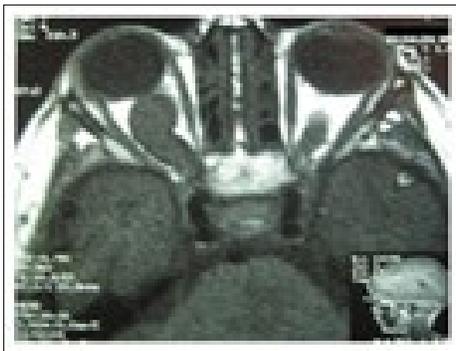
MRI: Right optic nerve glioma.
